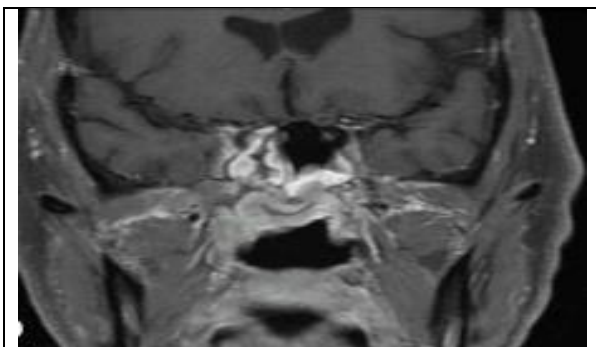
Preoperative MRI showing augmentation of the right temporal lobe and cavernous sinus.
